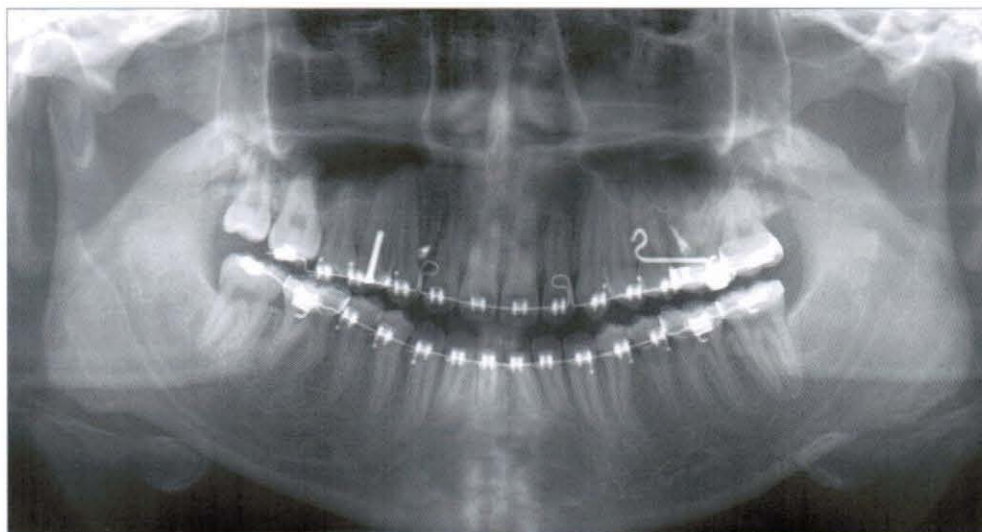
Panoramic radiograph taken at the detailing stage to check root parallelism (2006, 11,17). The positions of the upper right second molar and third molar roots are adequate.
